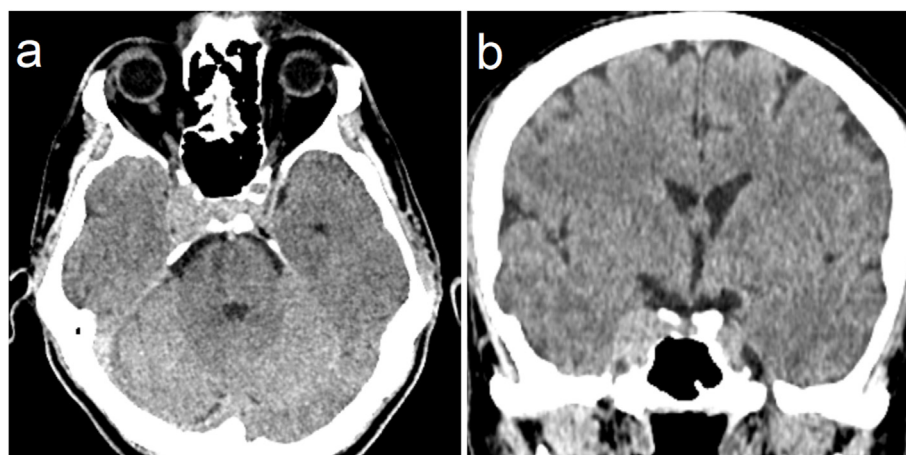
CT imaging of the right cavernous sinus capillary hemangioma in axial (A) and coronal (B) sections.
